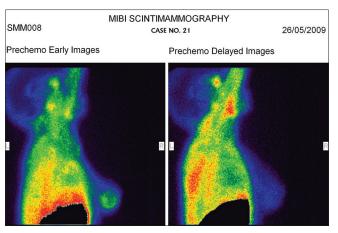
Patient no. 21 (nonresponder case) - shows early image and delayed image of scintigraphy studies, who showed no response to chemotherapy on pathological examination. It evidenced intense tracer uptake in tumor in early image and high wash out rate in delayed image predicting poor response to chemotherapy
